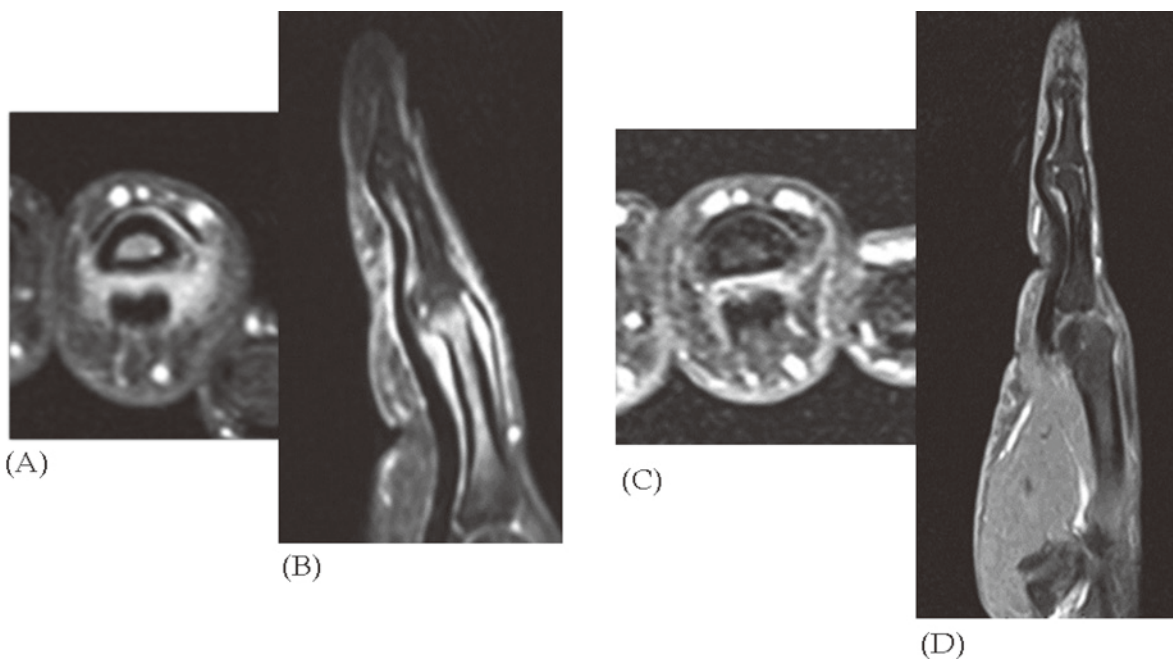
A 37-year-old Japanese man (patient 2) with pain and swelling of the right fourth finger. The biological agent was first infliximab and was then changed to adalimumab. Contrast-enhanced T1-weighted images with fat suppression left, axial right, and sagittal. (A) (B) Before treatment. There is moderate enhancement around the proximal interphalangeal (PIP) joint (synovitis ; score = 2). There is a slight enhancement along the tendon sheath at the PIP joint (tenosynovitis ; score = 1). There is a high signal in the proximal phalanx (bone marrow edema ; score = 3). (C)(D) Six months after treatment. There was little enhancement around the PIP joint (synovitis ; score = 1). The slight enhancement along the tendon sheath at the PIP joint had disappeared (tenosynovitis : score = 0). The high signal in the proximal phalanx is disappeared (bone marrow edema ; score = 0).
